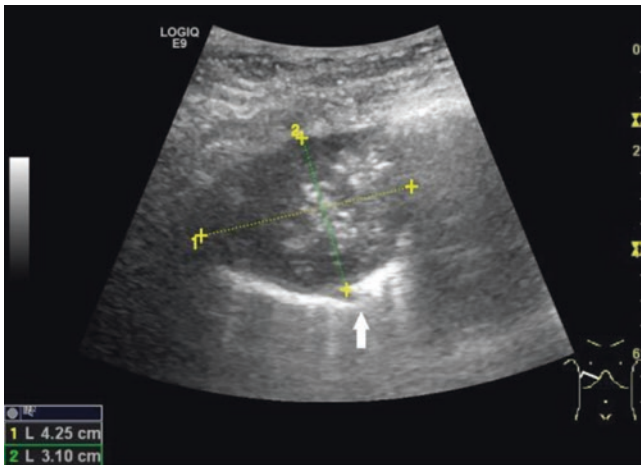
This 77-year-old man complained of pain in the right chest. Sonography revealed a large tumor formation extending from the lung to the chest wall and leading to osteolytic destruction of a rib (arrow). Sonography-guided biopsy indicated metastasis of a urothelial carcinoma operated on 2 years ago
